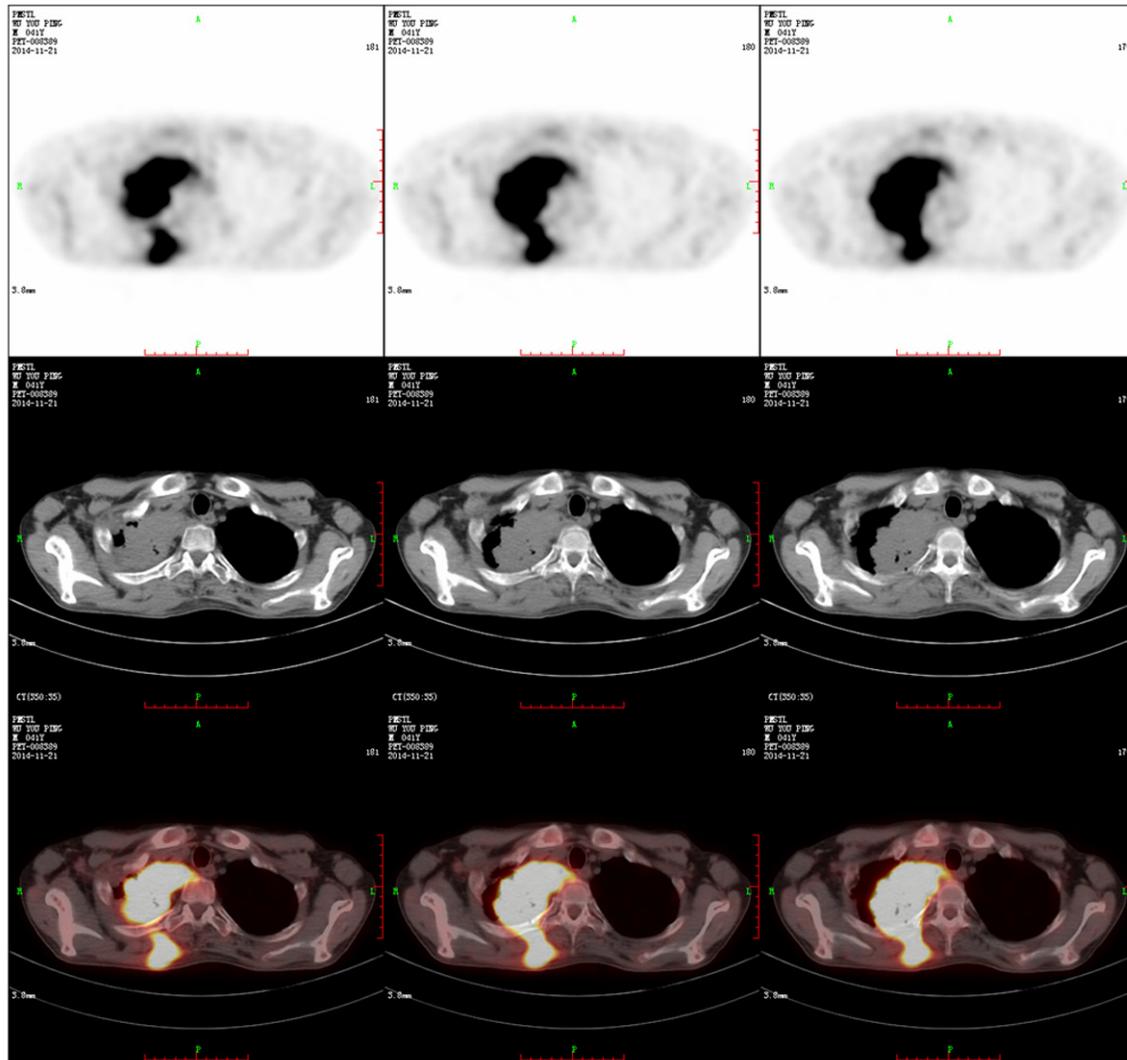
41-year-old man with pulmonary actinomycosis imitating lung cancer with PET/CT scan. The PET/CT showed a 7.0×8.5 cm mass in the upper lobe of the right lung, accompanied by increasing glucose metabolism.
